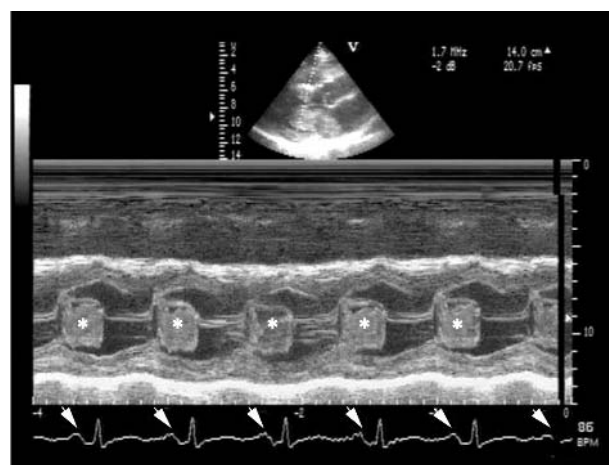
Further echocardiogram showing diastolic prolapse into the mid-left ventricular cavum, the patient remaining in sinus rhythm all the time.
